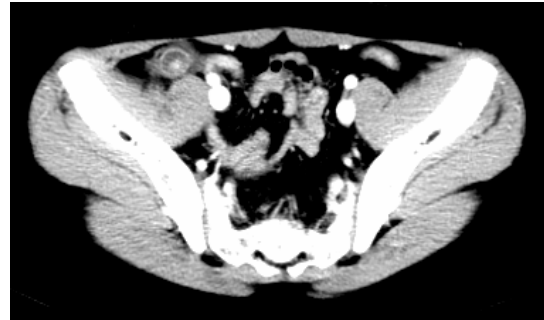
CT scan showing thickened wall of the fluid-filled appendix. An appendicolith is also present.
